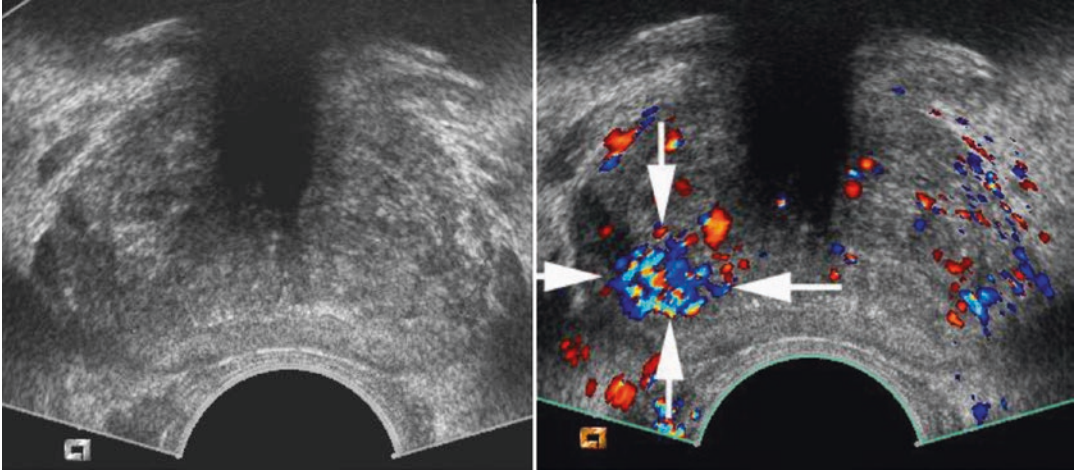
Prostatic neoplasm with isoechoic structure, evidenced with ecocolor Doppler help, with contrast medium (white arrows)
